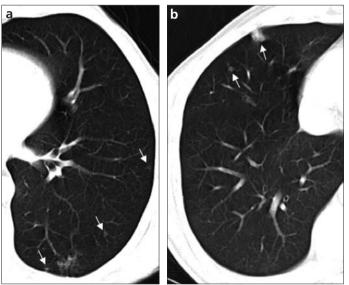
a, b. Axial CT images (a, b) show multiple nodules (arrows) in both lungs.
